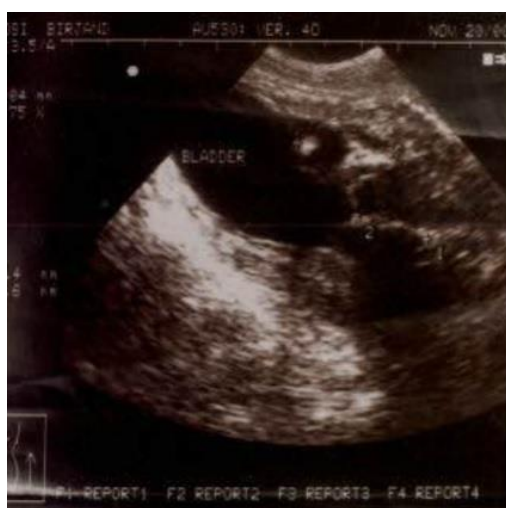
Ultrasound; an echogenic curved mass with obvious posterior shadow
